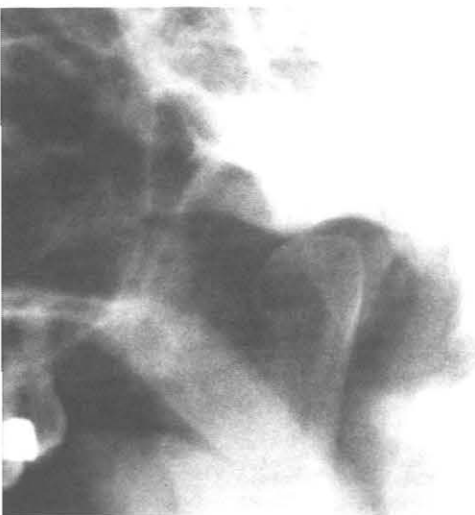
Transpharyngeal radiograph of the right TMJ.
